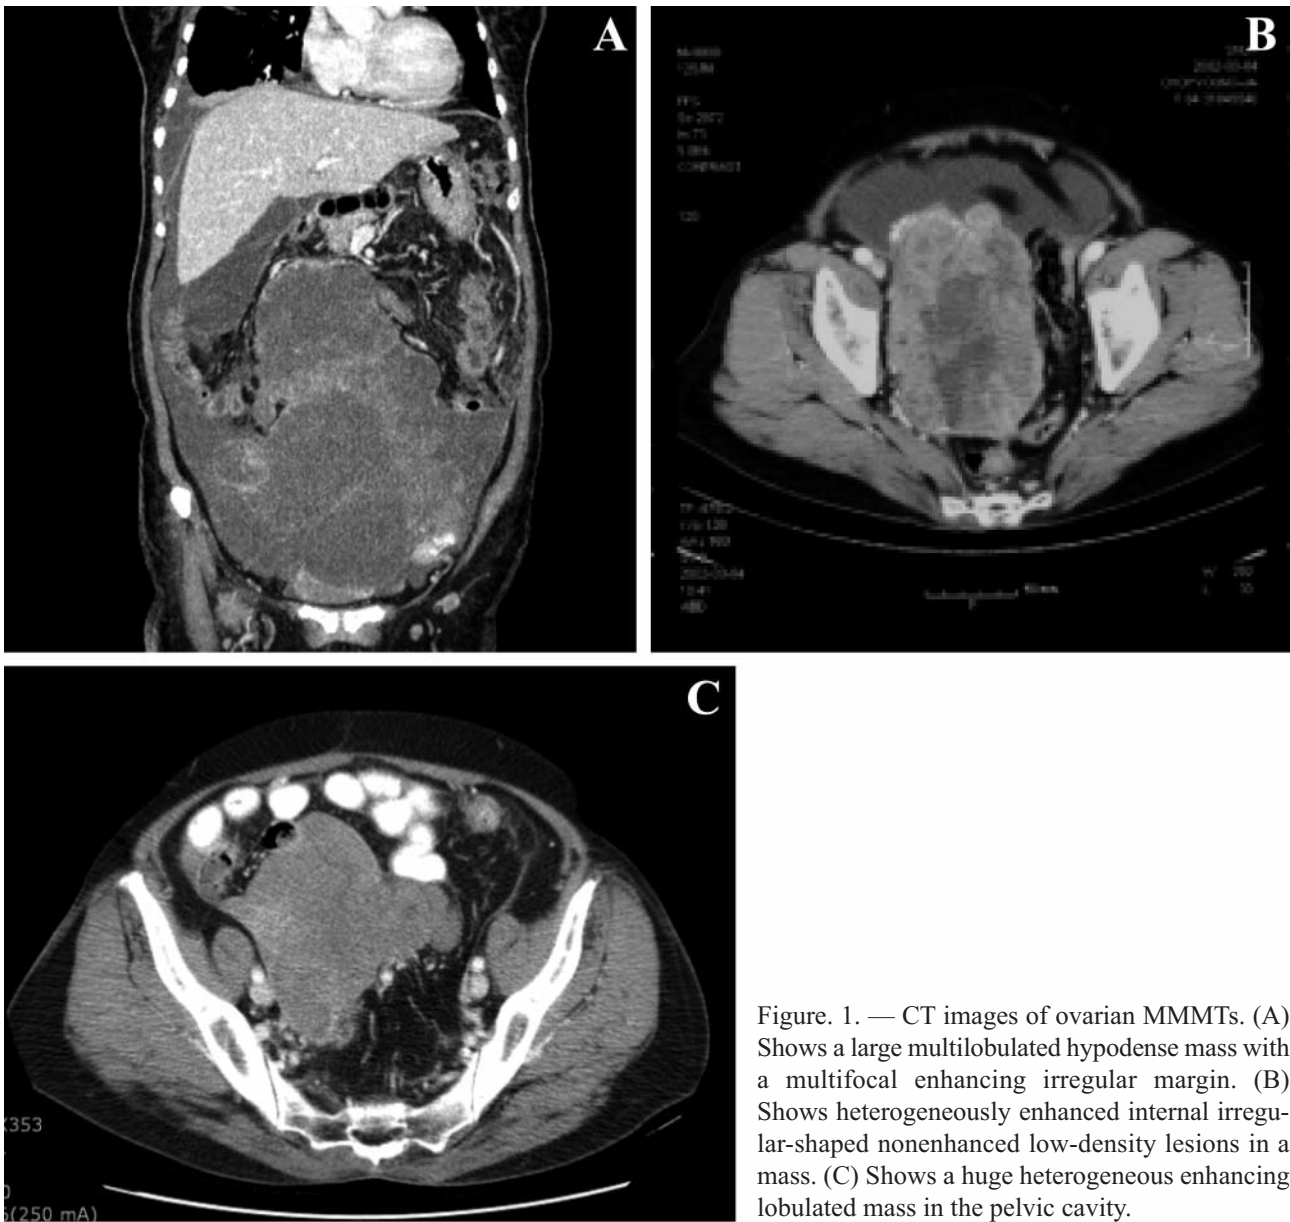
CT images of ovarian MMTs. (A) Shows a large multilobulated hypodense mass with a multifocal enhancing irregular margin. (B) Shows heterogeneously enhanced internal irregular-shaped nonenhanced low-density lesions in a mass. (C) Shows a huge heterogeneous enhancing lobulated mass in the pelvic cavity.
